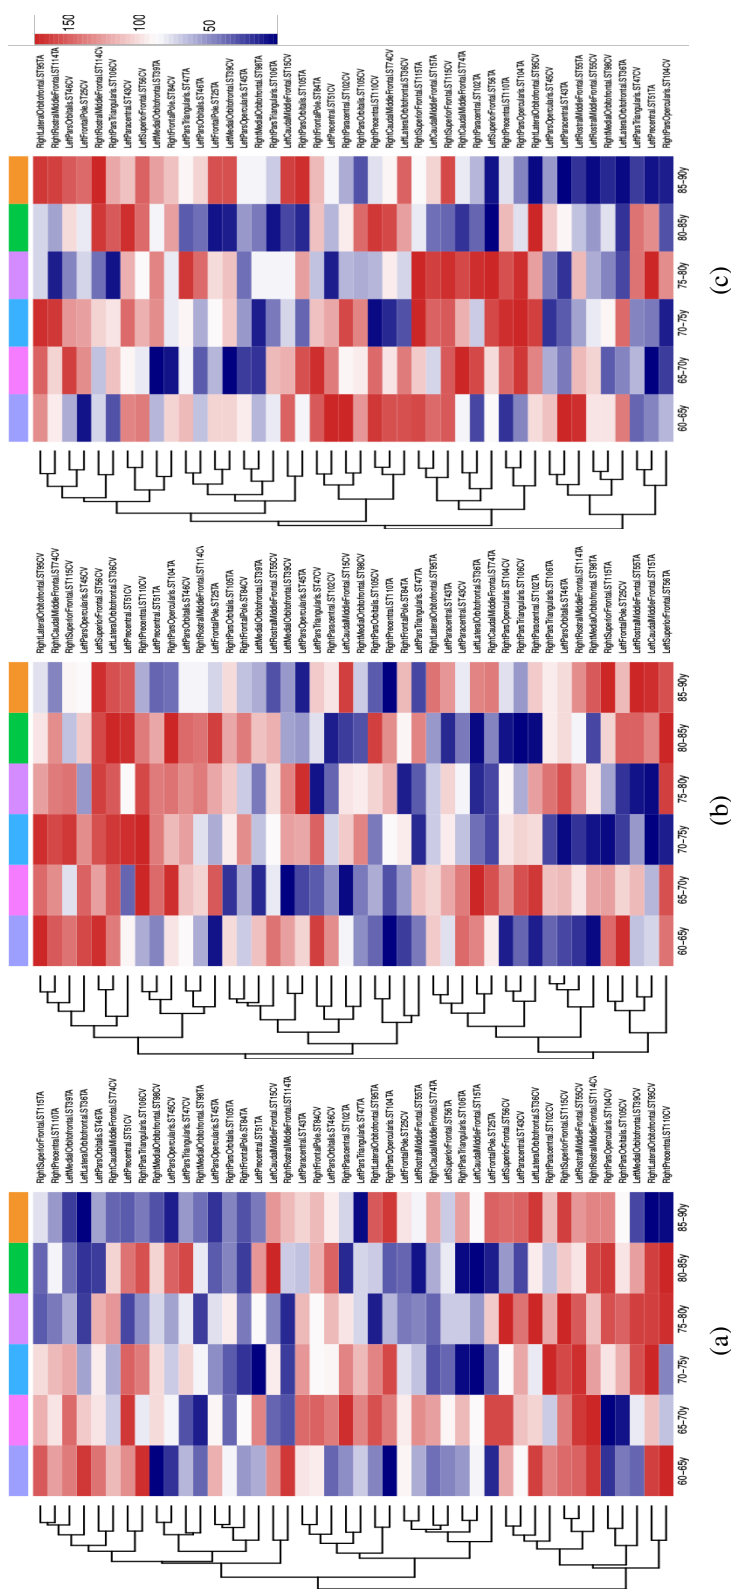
mRMR ranking achieved by the MRI biomarkers of the frontal lobe. (a) AD vs HC. (b) MCI vs HC. (c) AD vs MCI. Red colours mean that features were in the lowest ranking positions; blue colours mean that the features ranked in the first positions.
